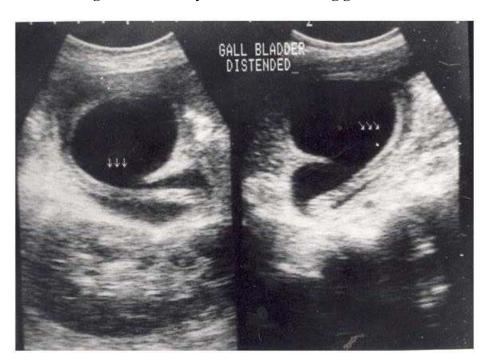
Ultrasound abdomen showing gall stones in gall bladder
